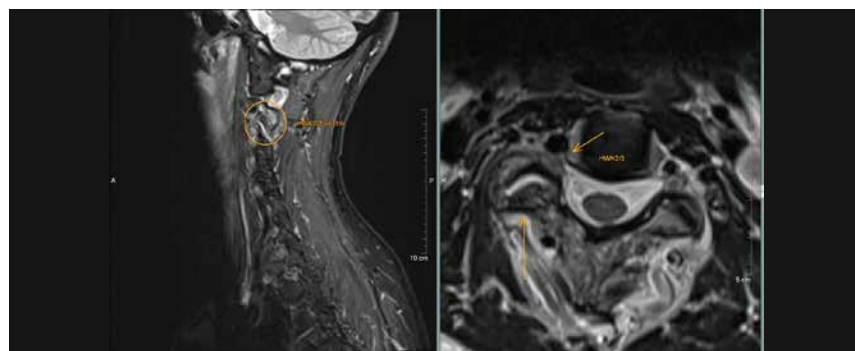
MRI: isolated unilateral hypertrophic osteoarthritis of the right C 2/3 facet joint with activation demonstrated by bone marrow oedema, articular effusion and extensive periarticular soft-tissue oedema: higher-grade right foraminal stenosis as a consequence of this.
